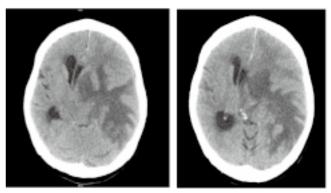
CT brain showed extensive white matter edema and gross midline shift.
